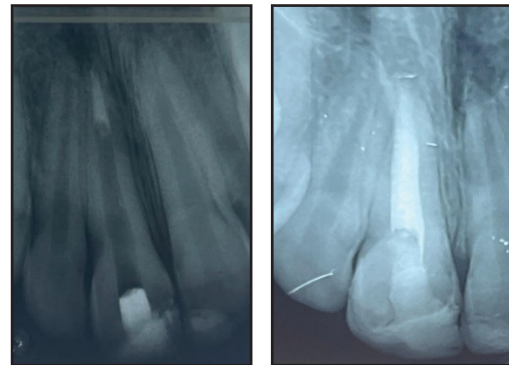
MTA root end fillings to manage a large periapical lesion. Note the healing of the Periapical lesion.
